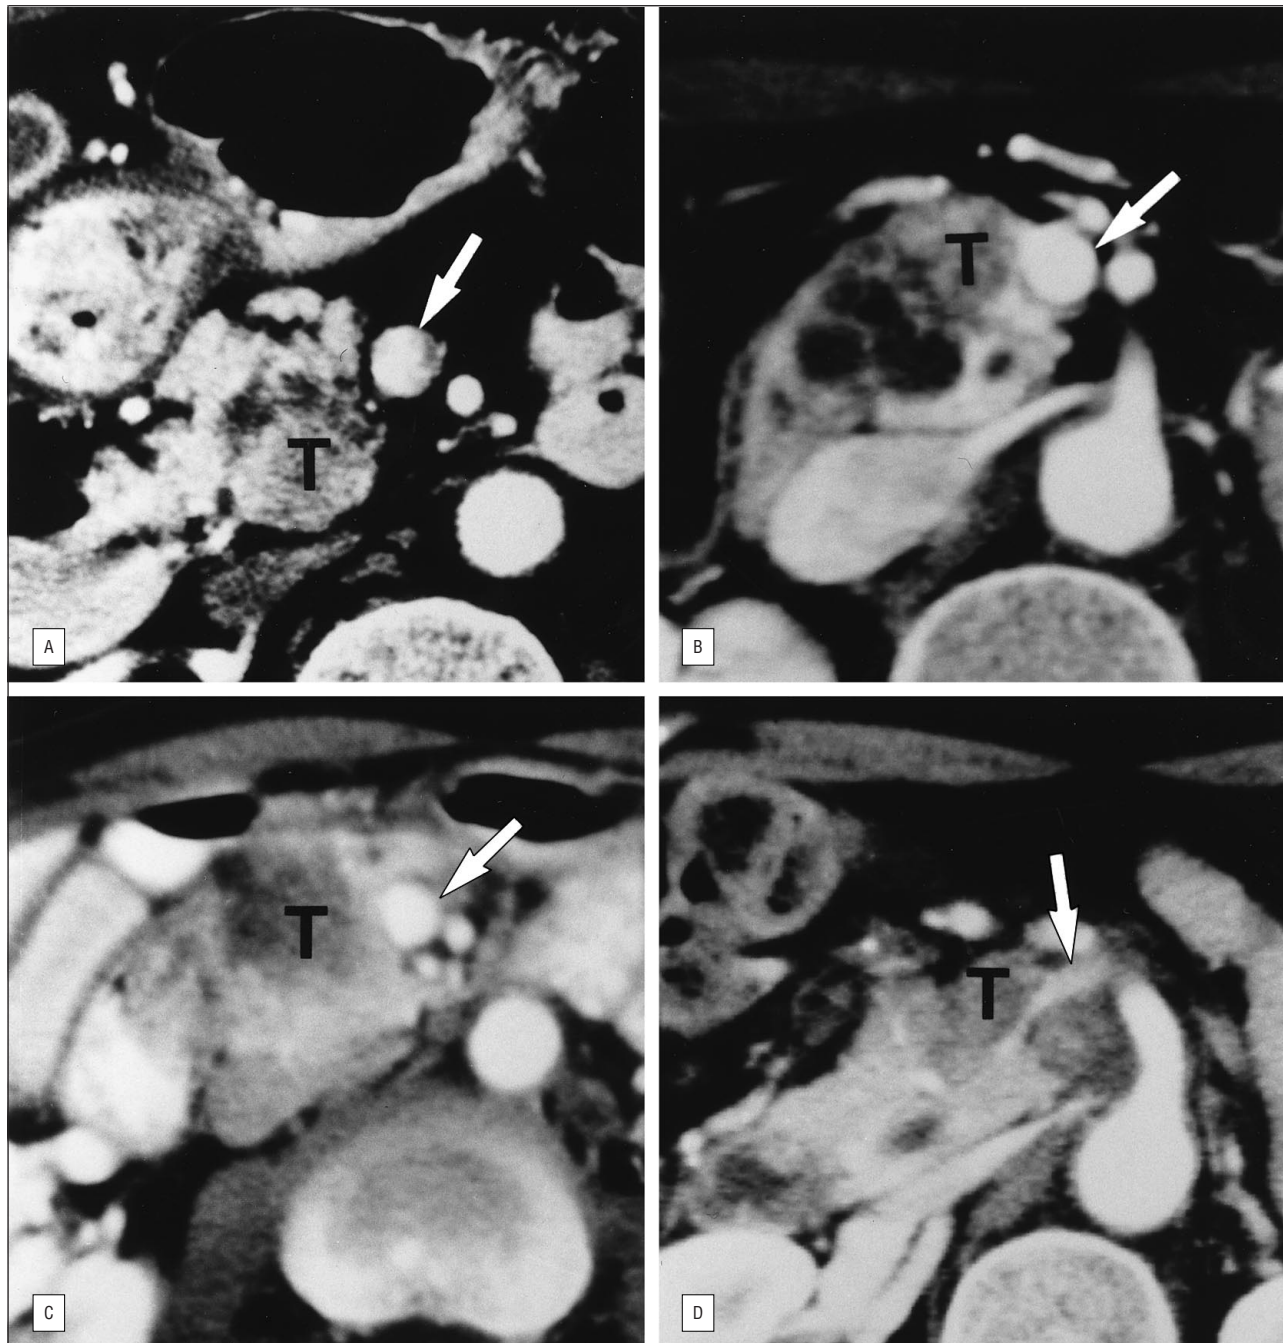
Helical computed tomography typing of portal vein (arrows) invasion. A, Type 1, presence of a fat plane between the portal vein and tumor (T). B, Type 2, contact between tumor and portal vein was evaluated as 90° or less. C, Type 3, contact ranged between 91° and 180° . D, Type 4, contact greater than 180° .
